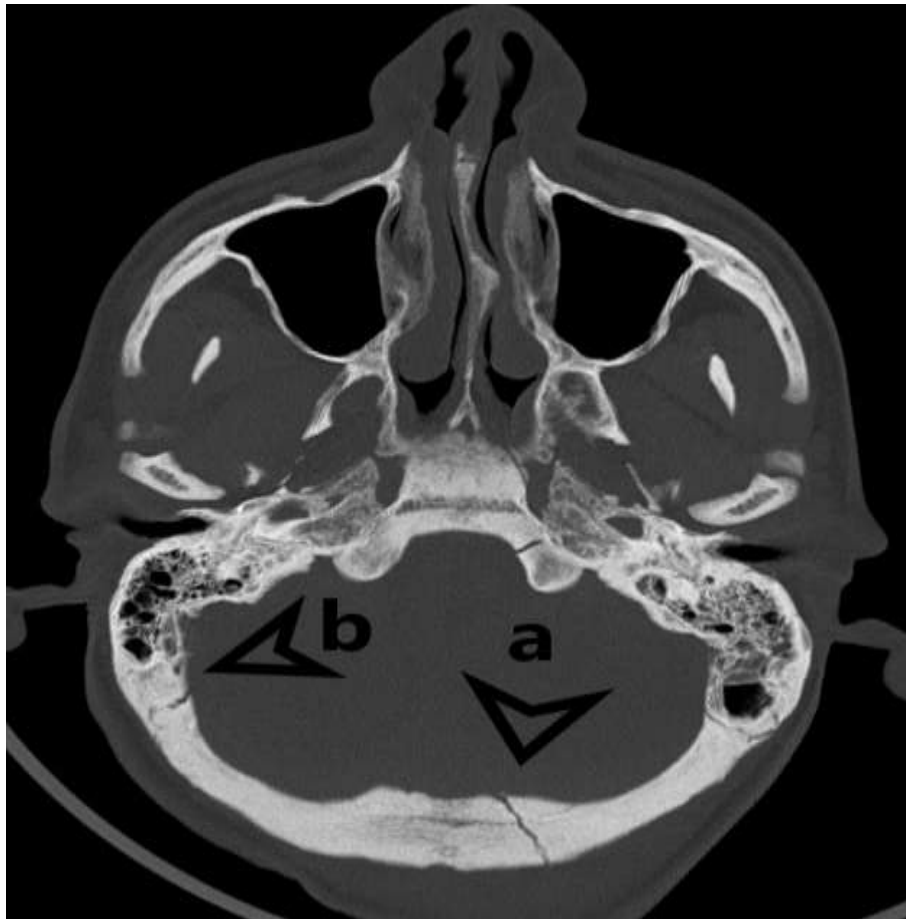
Axial section of CT scan of skull showing fracture with arrow head 'a' and wormian bone with arrow head 'b'.
